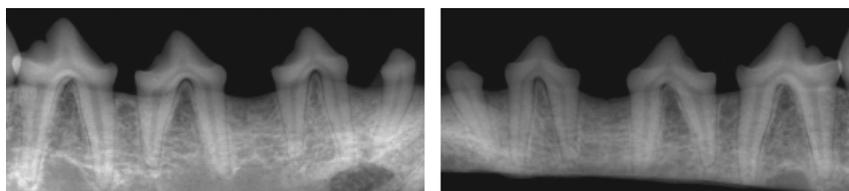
Representative radiographs of second and fourth mandibular pre-molar sites implanted with the recombinant human growth/differentiation factor-5/poly(lactic-co-glycolic acid) construct or serving as sham-surgery control. There are no appreciable differences between pre-molar sites in this case representing 4- (right) and 2-week (left) observations. The radiographs of the experimental sites show conditions comparable to that of the untreated third mandibular pre-molars.
